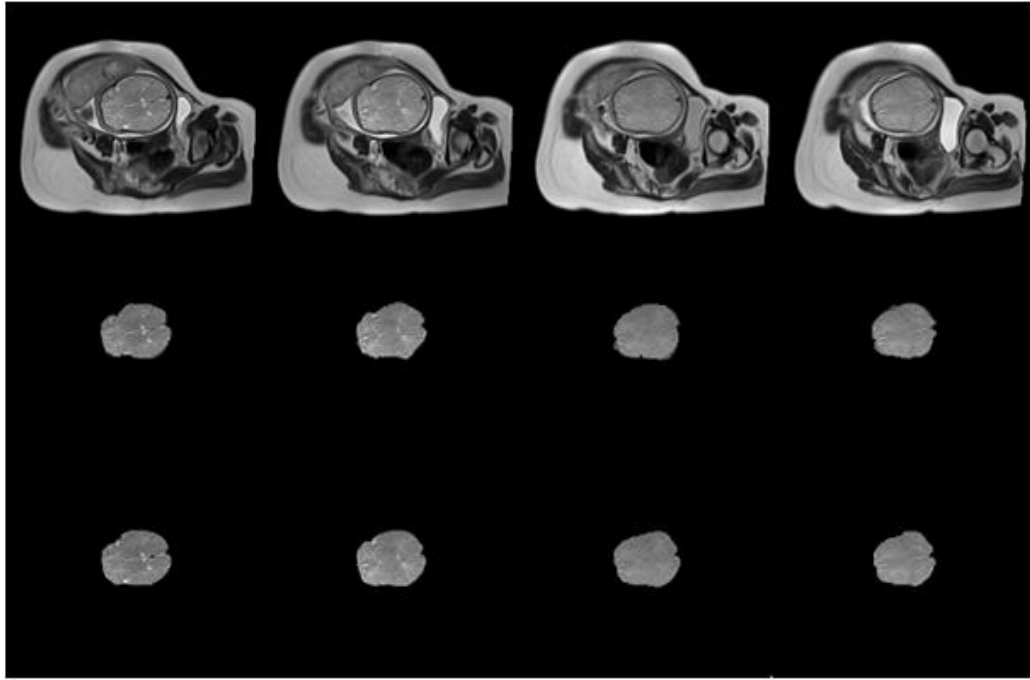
Coronal view of a segmented fetal brain obtained via MRI scan. Row 1: original MRI images, row 2: manual segmentation, row 3: proposed result.
